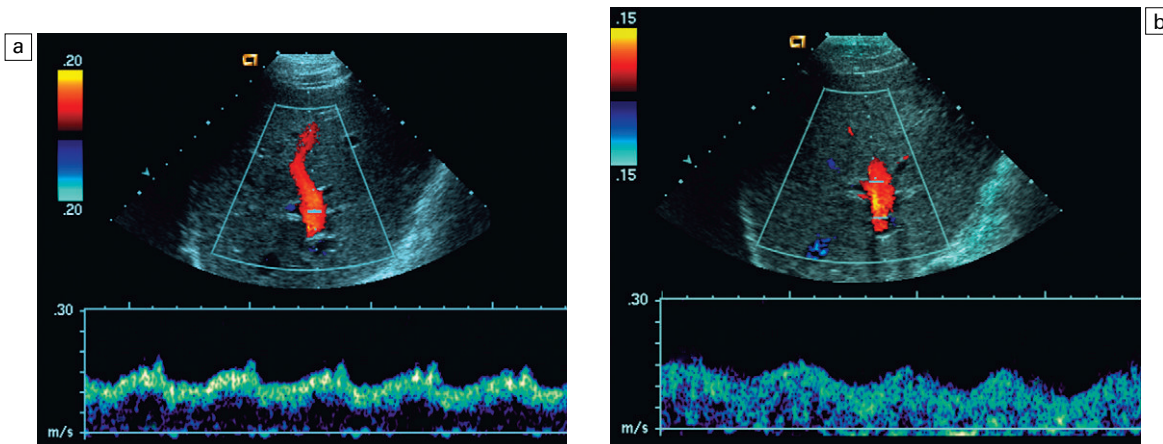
(a) Spectral Doppler tracing of a portal vein with small, centrally placed sample volume. A thin lamina of flow is interrogated and, therefore, the displayed tracing shows a narrow range of velocities with a 'window' below the tracing. (b) The sample volume has been opened wide to incorporate all velocity lamina across this portal vein. Note the 'filling in' of the spectral tracing resulting in a perception of spectral broadening.
